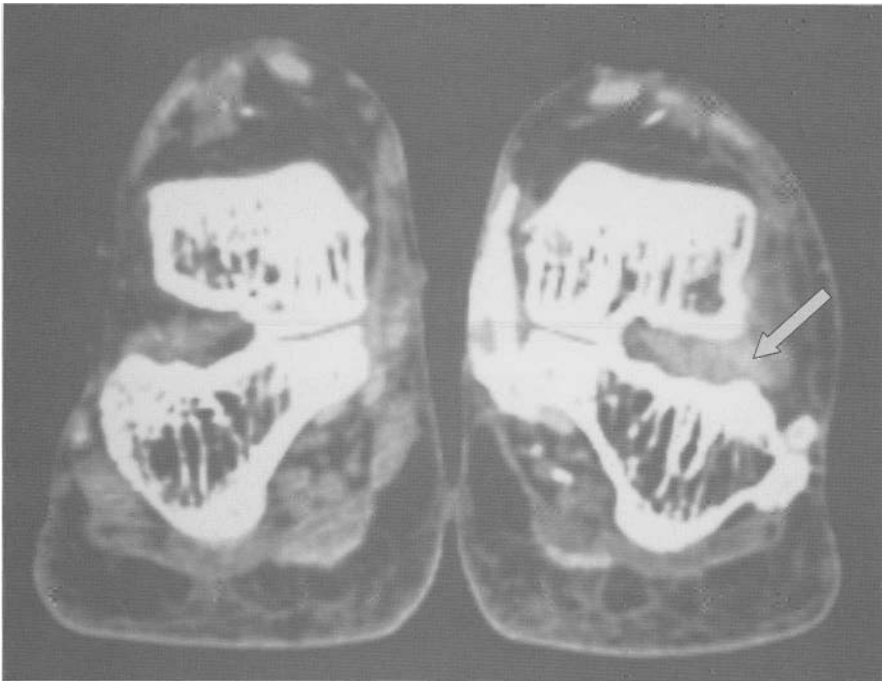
CT: soft tissue window. Bilateral sinus tarsi pannus (arrows).
